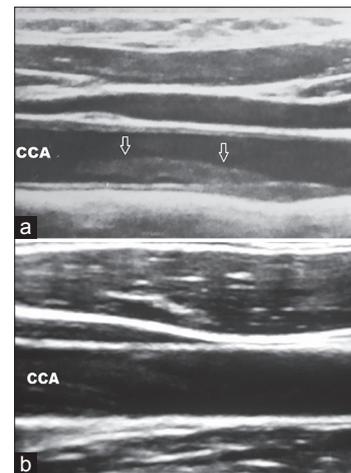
Duplex ultrasound examination revealing: (a) Free-floating thrombus in the left common carotid artery (b) No residual lesion after the thromboendarterectomy (Postoperative 7th day)
